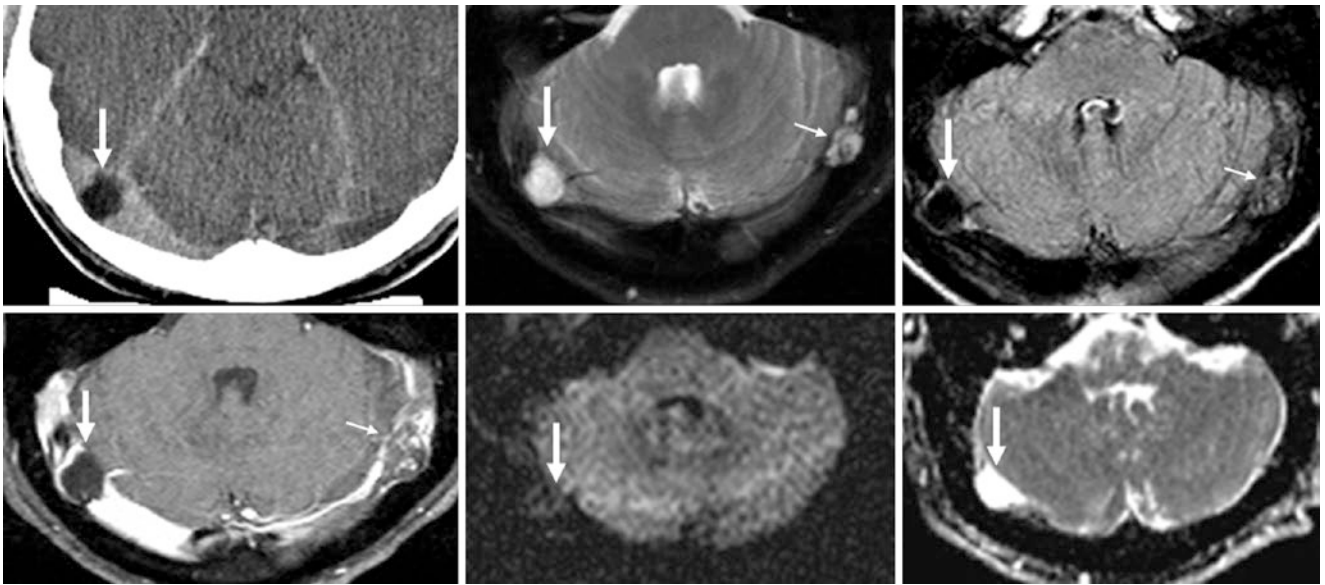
Top row:* 38-year-old with a well-circumscribed, typical right TS arachnoid granulation (*large arrows*) on contrast-enhanced CT (*left*), with density of CSF, also following CSF on T2WI (*middle*) and FLAIR (*right*). *Bottom row:* this typical granulation did not enhance on
